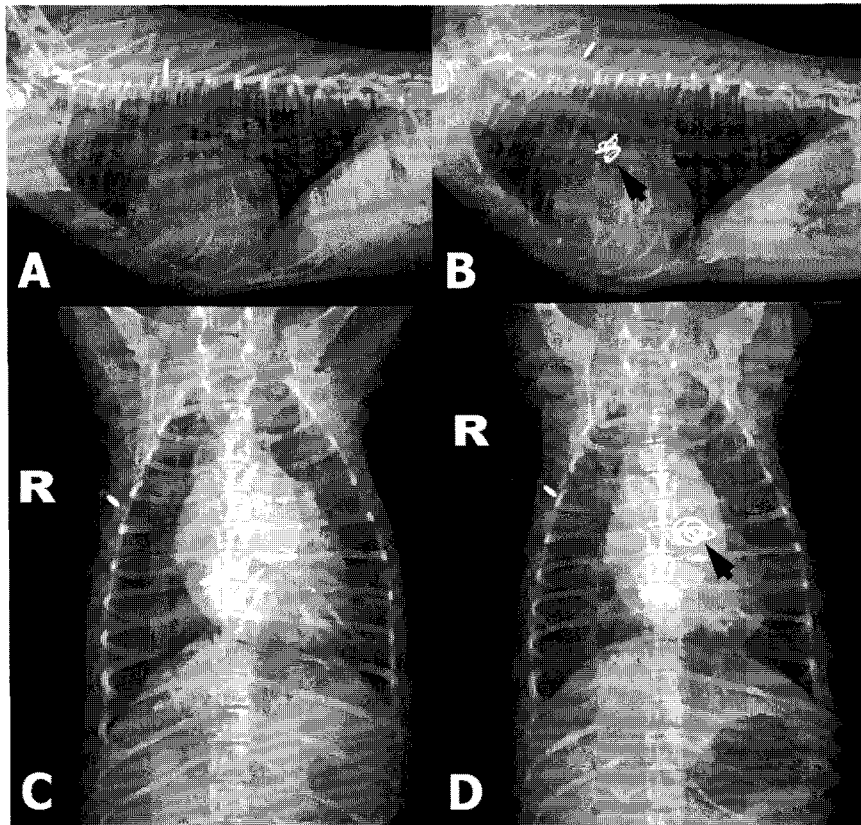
Thoracic radiography obtained before and after the PDA occlusion. Right lateral and dorsoventral radiograph demonstrating cardiomegaly and pulmonary overcirculation secondary to PDA (A, C). After the PDA occlusion, the coil (arrow) is positioned in the ductus and reduction of cardiomegaly and pulmonary overcirculation were noted (B, D).
